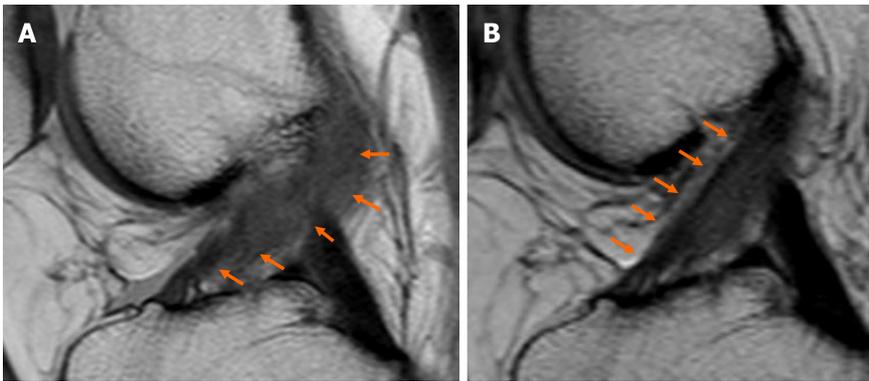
Magnetic resonance images. A: Baseline magnetic resonance imaging (MRI) showed widening of anterior cruciate ligament (ACL) fibers with continuity of fibers (orange arrows). Total score of 4 points according to Van Meer's classification; B: Six months after platelet-rich plasma injection, MRI showed an improvement in the signal intensity as well as tension of ACL fibers (orange arrows). Total score of 0 points according to Van Meer's classification (MRI sequence: sagittal proton density weighted turbo spin echo).
